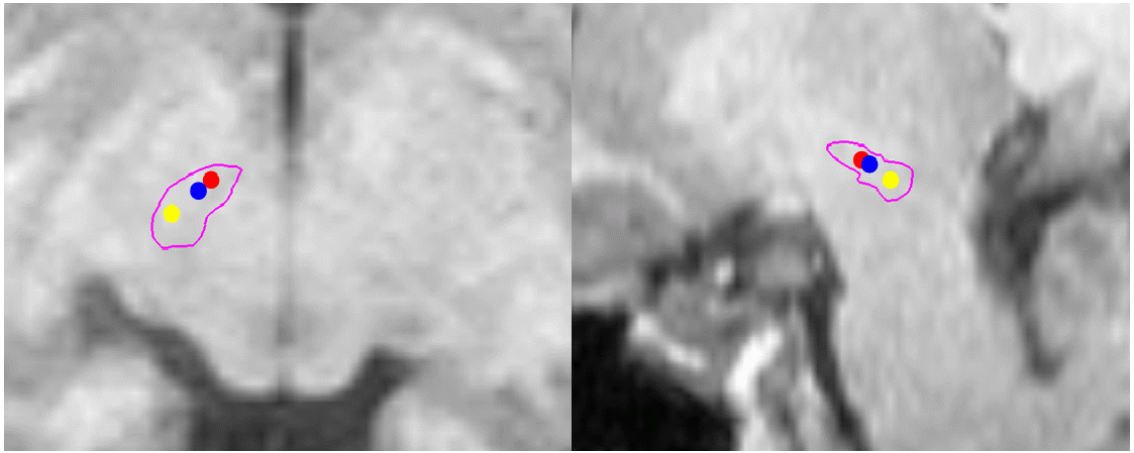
Zoomed axial (left) and sagittal (right) slice of a subject pre-op MR image with the automatically segmented STN contours (in purple). Blue dot shows the actual implant location, red dot shows the automatically predicted implant location by our algorithm and yellow dot shows the manually selected implant location. Note the close proximity of the automatically predicted implant location to the actual implant location.
